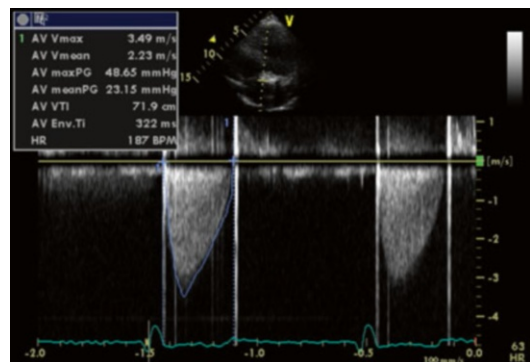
Continuous Wave (CW) Doppler of the aortic valve mechanical prosthesis
